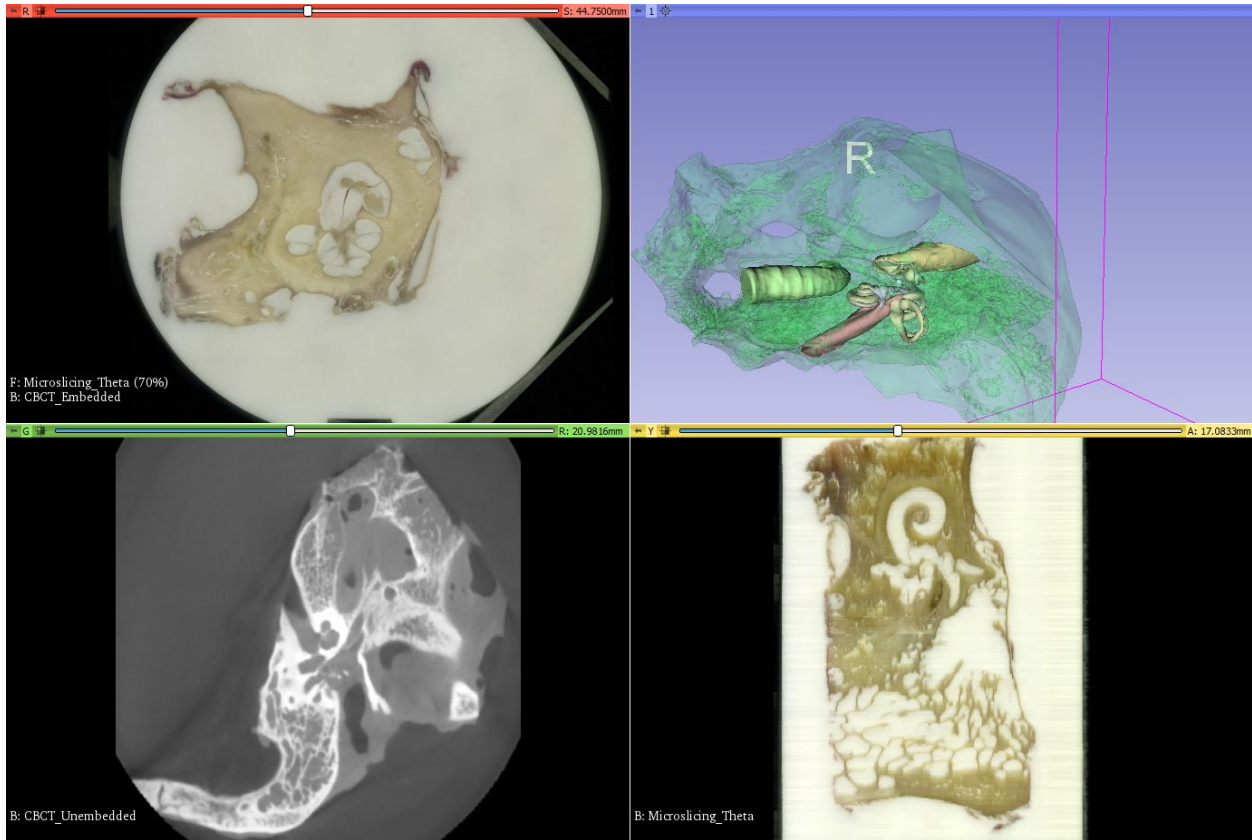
3D segmentation and slices of the Micro CT of the temporal bone and cochlea.
